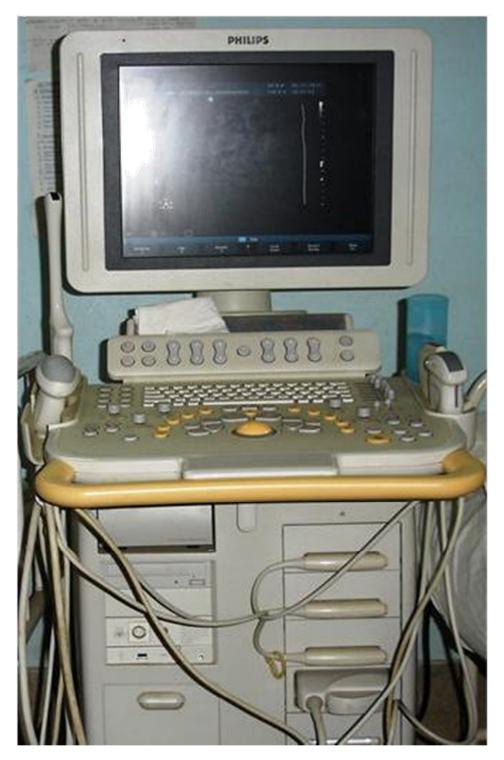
Ultrasound equipment : PHILIPS HD 11XE
